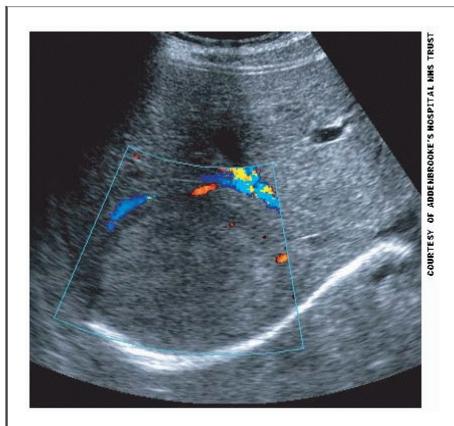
Ultrasound of the liver showing a solitary round mass in the posterior aspect of the right lobe of the liver. This was a primary liver tumour. Duplex imaging shows a leash of vessels surrounding the lesion but not within it, suggesting it is not a highly vascular tumour.
